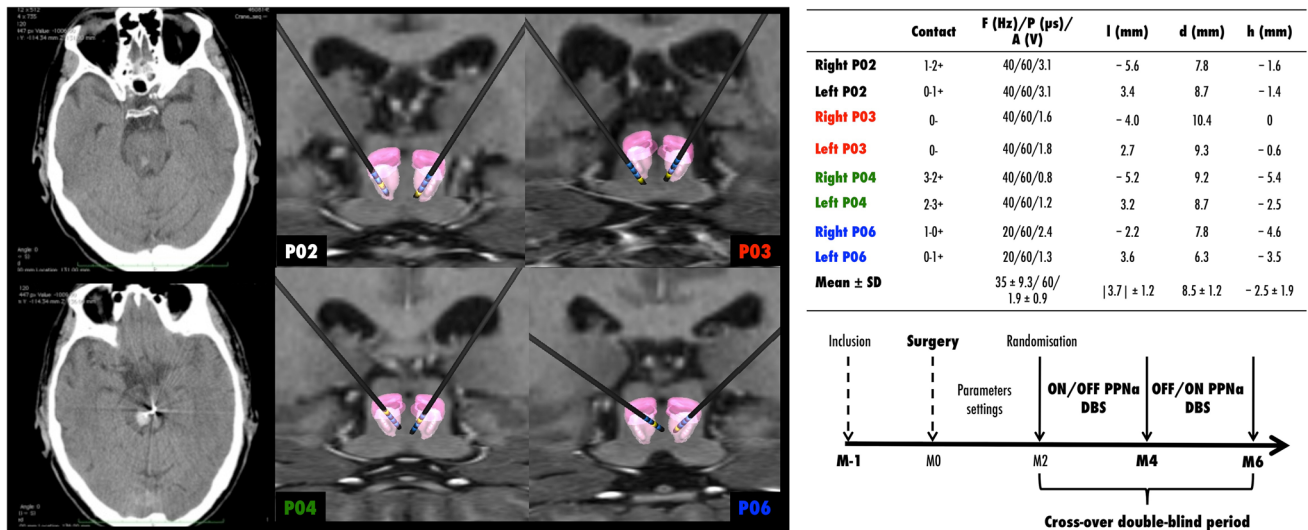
Electrode locations and design of the study. *Left* Post-operative CT-scan in patient 5, who experienced a midbrain haemorrhage. *Middle* Magnetic resonance images showing the contact locations used for chronic PPN stimulation in the four PD patients. Active contacts are yellow (cathode) and non-active or anode contacts are blue. Anterior frontal view with 3D atlas reconstruction showing the PPN (transparent pink) and the cuneiform nucleus (solid pink). *Table* Parameter settings and coordinates of the stimulating
